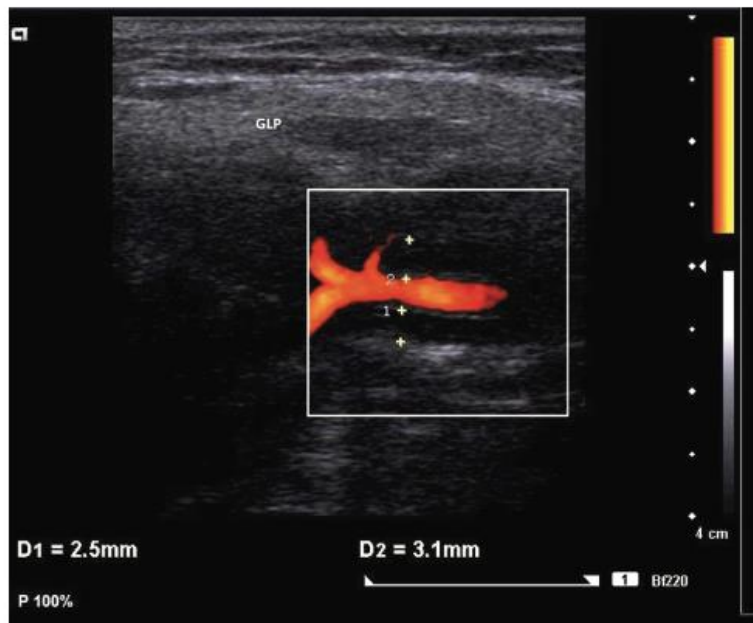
Ultrasound imaging of the left temporal artery demonstrating a markedly thickened vessel wall measuring 2.5 mm and 3.1 mm.
